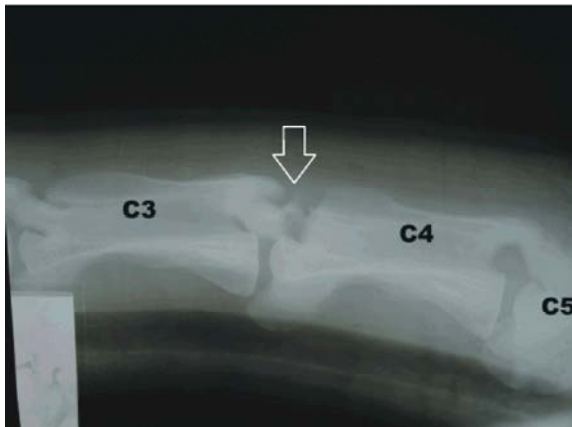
Lateral radiograph of the neck, flexed position, in a llama affected by fracture of the articular facet of the fourth cervical vertebra. Note the large bone fragment and fracture of C4 (arrow).
